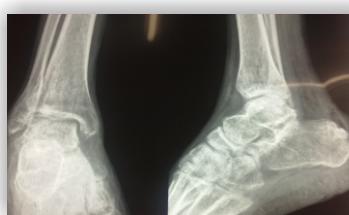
Radiograph at 8 wks showing good fracture union.
